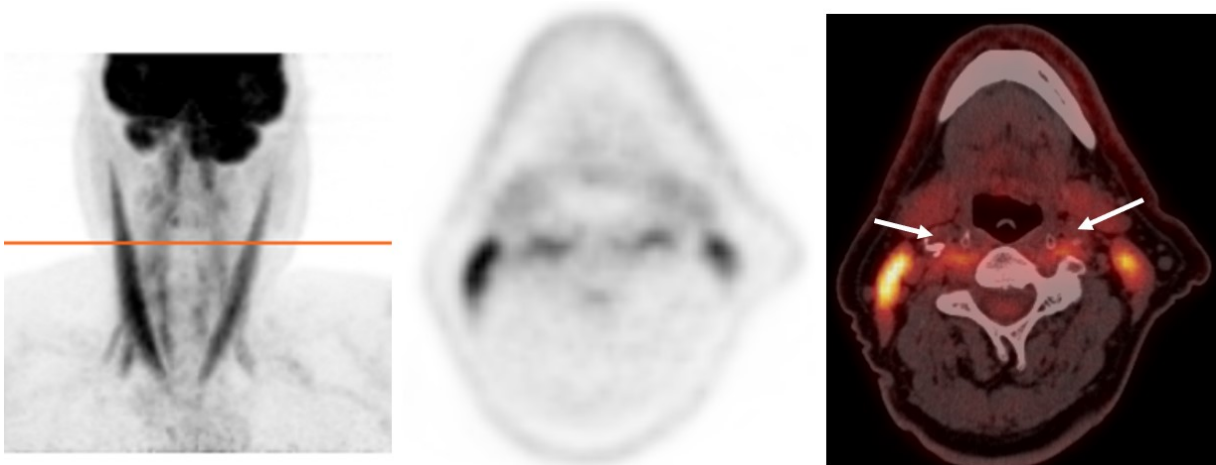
High uptake of ^{18}F -FDG in neck muscles close to the plaques in the carotid arteries (white arrow points at the lumen in the common carotid arteries in the image to the right).
